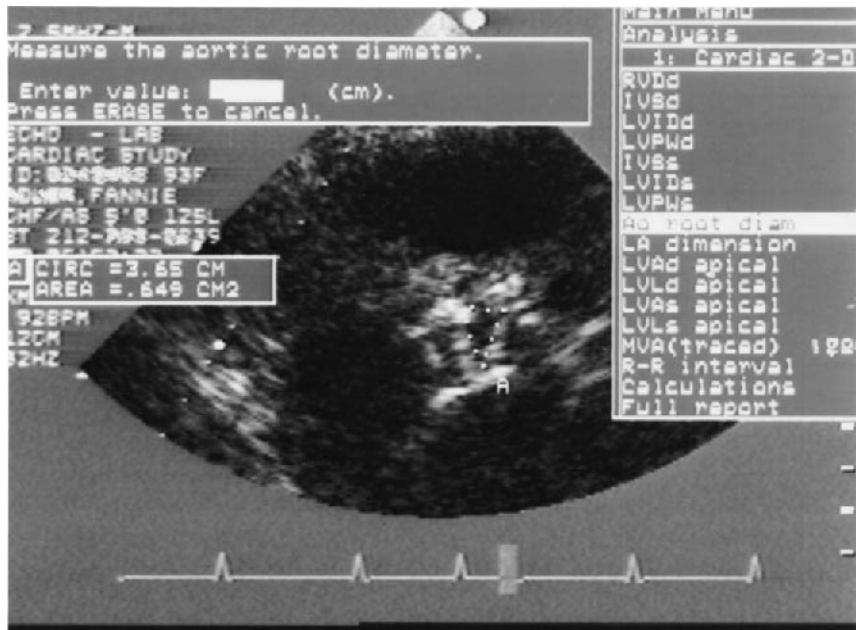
Two-dimensional echocardiographic image obtained in the same patient in Figures 1 and 2 from a short-axis parasternal view in which the aortic valve orifice is mapped, yielding an indexed area of $0.4 \text{ cm}^2/\text{m}^2$.
